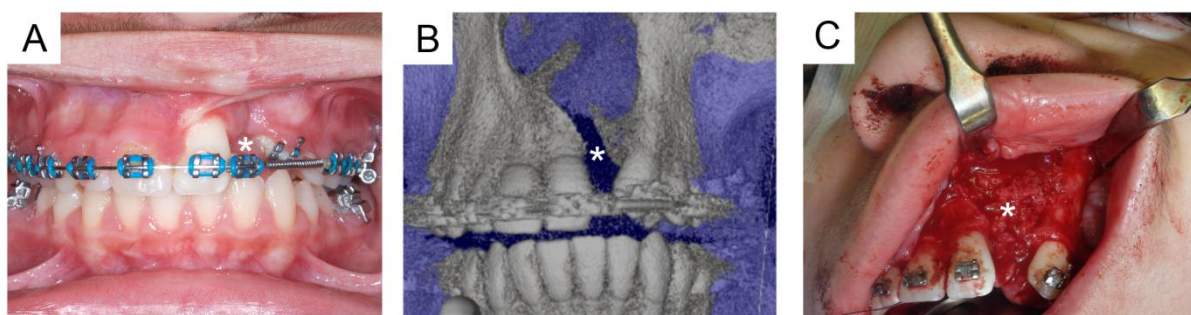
Alveolar bone grafting at preteen age. Although the gum of the alveolar maxillary parts are in contact a broad gap in the dental arch remains (A, *). The width of the alveolar part of the maxilla is seen in the radiography (B, *). Cancellous graft from the patient's pelvic bone is used to fill the alveolar cleft and to form a bony bridge between both maxillary parts (C, *).
